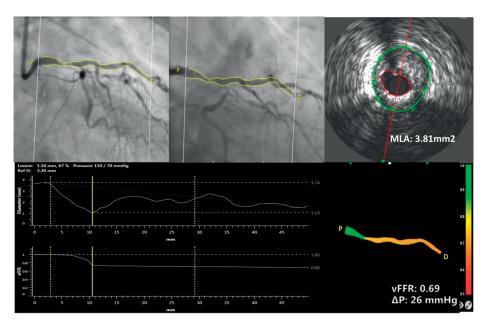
Case example of three-dimensional reconstruction of left main coronary artery (LMCA) and computation of vessel fractional flow reserve (vFFR), using two angiographic projections with at least 30 degrees apart and invasively measured aortic root blood pressure. Quantitative lumen assessment by intravascular ultrasound in LMCA.
